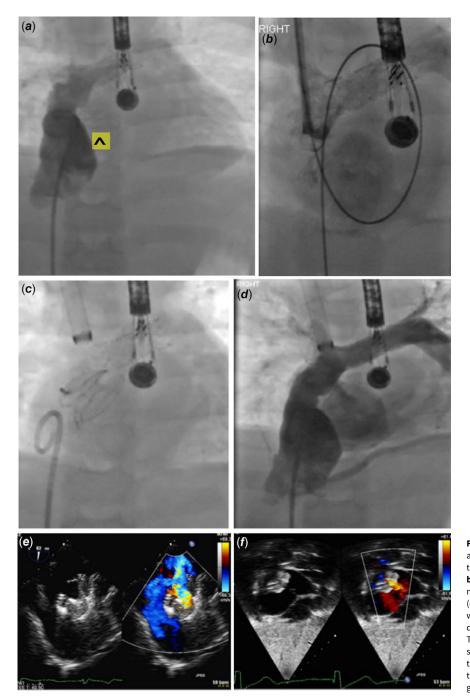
(a) Angiogram performed via femoral venous access with catheter placed in lateral tunnel showing no flow through the baffle stent with contrast injection (indicated by ^); (b) Angiogram after Atlas balloon dilation of the neofenestration demonstrating no extravasation of contrast; (c) and (d) Angiogram performed via femoral venous access with catheter in lateral tunnel showing Atrial Flow Regulator device and flow through it with contrast injection; (e) Transoesophageal echocardiogram during the procedure showing Atrial Flow Regulator device; (f) Transthoracic echocardiogram the day after the procedure showing Atrial Flow Regulator device with good flow through the device.
